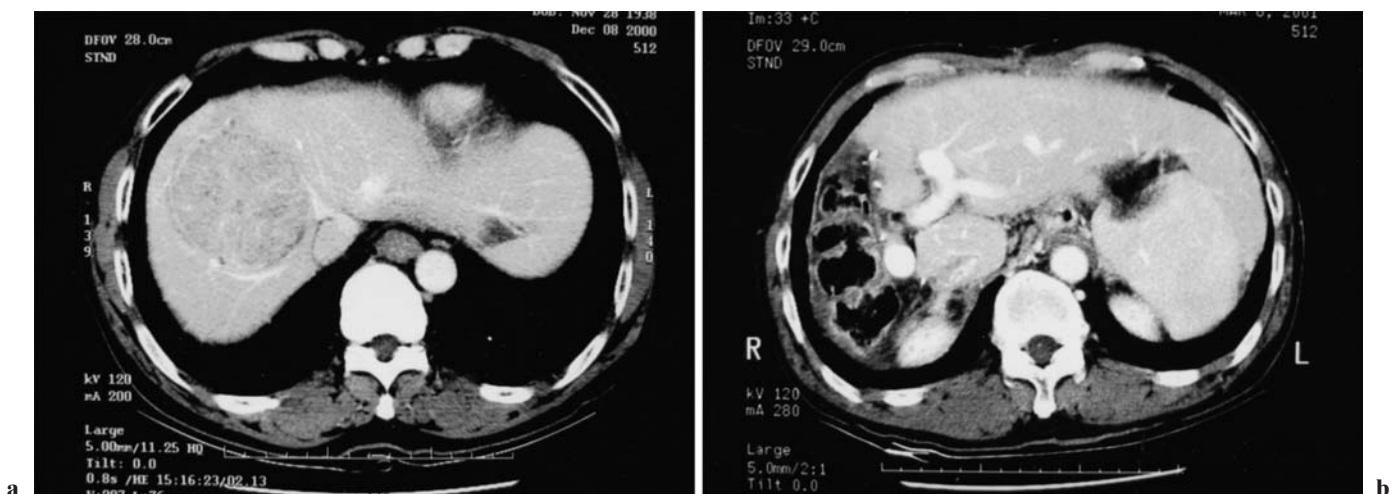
a,b Computed tomography (CT) scan of a patient with a hepatocellular carcinoma 9 cm in diameter closely related to the middle hepatic vein. There was associated cirrhosis and the preoperative indocyanine green retention at 15 min was
